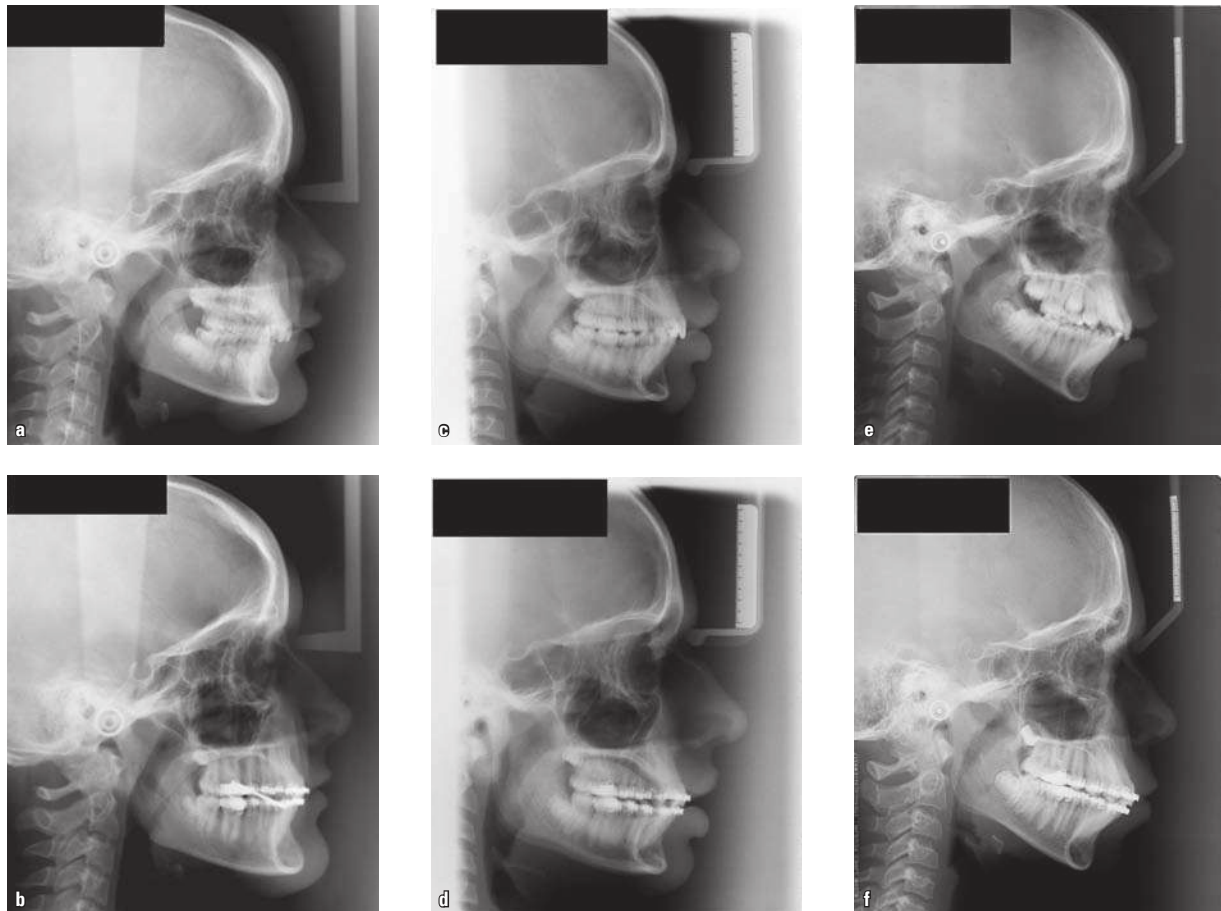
Initial and final lateral radiographs of the face of several patients who made use of MPA and show what appears to be the unavoidable buccal tipping of lower incisors.
